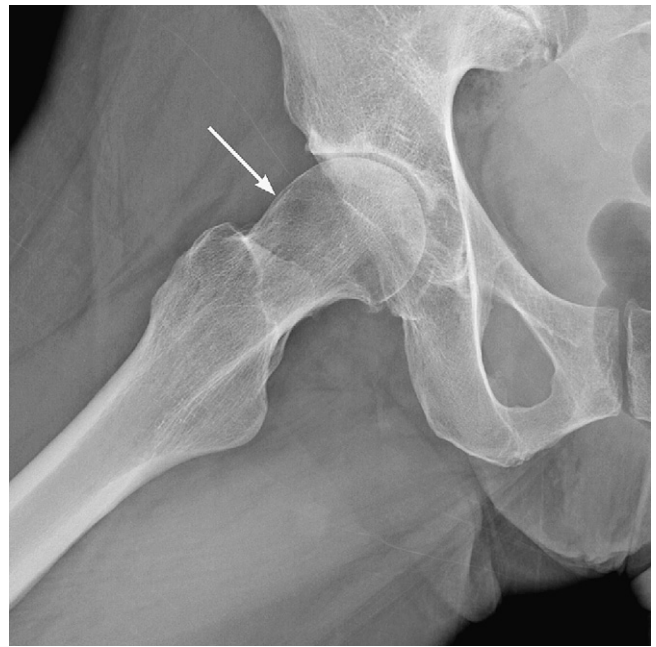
Frog lateral radiograph view shows a loss of the normal concavity along the superior femoral head–neck junction (arrow).
